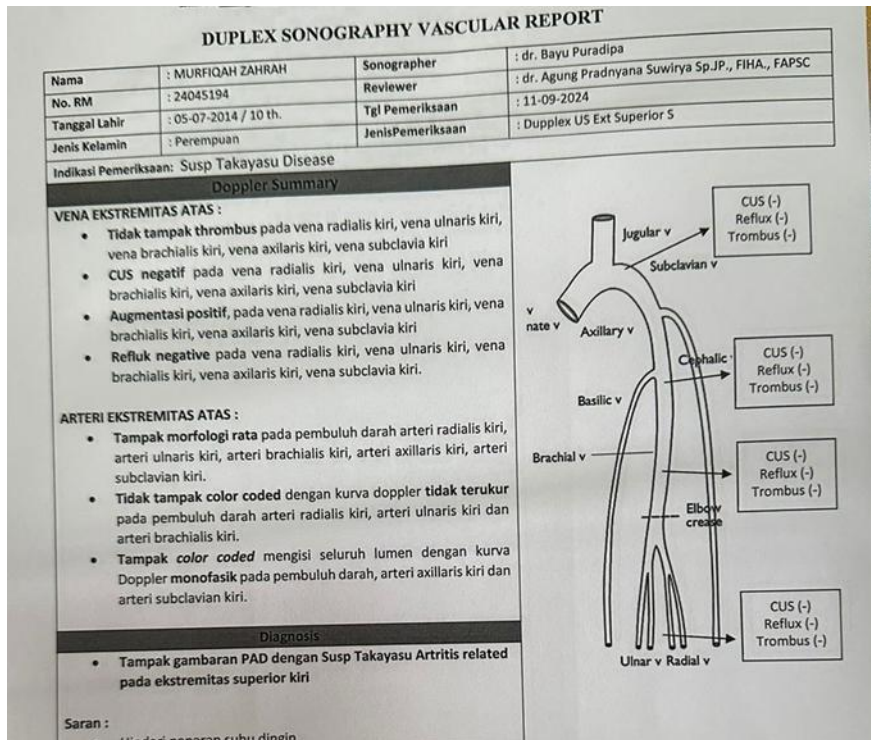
Results of the left superior superior vascular Sonography examination
